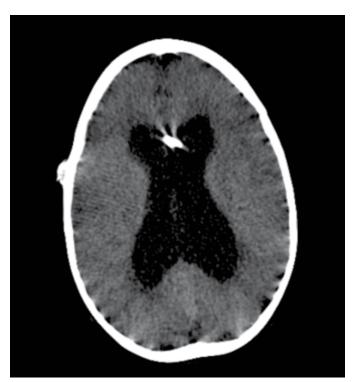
Computed tomography scan of the head without contrast enhancement demonstrating hydrocephalus.
